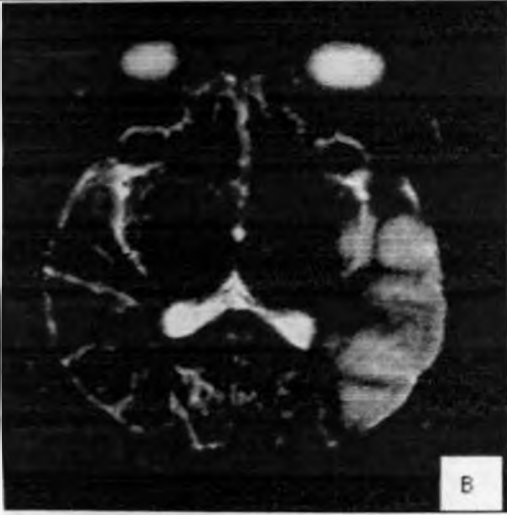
(B): T2-weighted MR show 12 hour old left MCA infarct. There is a hyperintense region on the left in the territory of middle cerebral artery.
